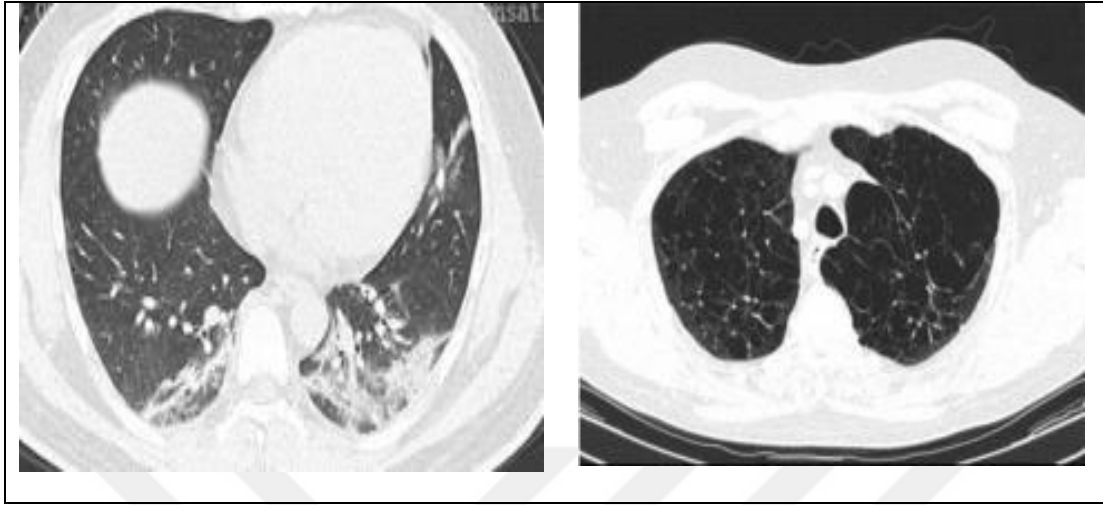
Positive (left) and negative COVID CT images from the proposed dataset.
